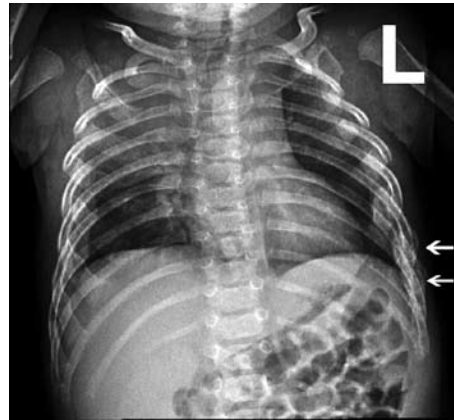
Chest x-ray showing bilateral multiple rib fractures.
